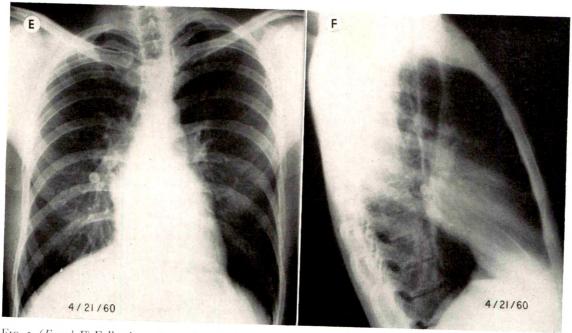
(E and F) Following 4 days of medical management, the re-examination of the chest shows complete clearing of the findings indicative of interstitial edema. Comment. This case demonstrates some of the typical findings of acute interstitial pulmonary edema. It further demonstrates that despite no significant symptoms or physical findings, pulmonary edema was present and was detected only by roentgenographic study. Also demonstrated is the rapidity of clearing of the roentgenographic findings following the institution of proper therapy.
